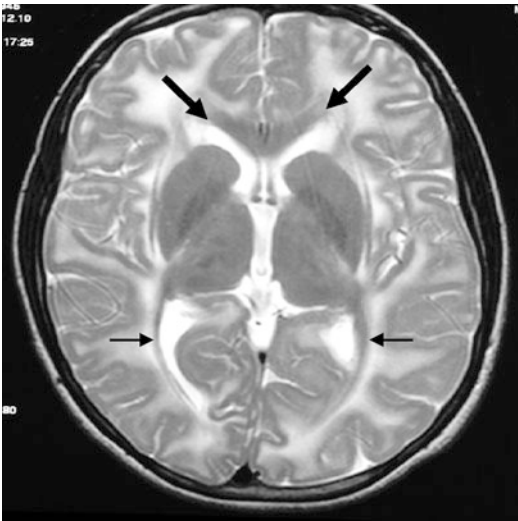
A 15-year-old Caucasian female was evaluated for megalencephaly and possible leukodystrophy. Early developmental status was normal except for the presence of macrocephaly. She had a bicycle accident with trauma to her head, followed by a generalized tonic-clonic seizure 7 months later. At 15 years of age, she had striking macrocephaly (head circumference of 65 cm), receiving special education, and was found to have mild bilateral clonus axial T1-weighted scan that demonstrates hyperintensity throughout cerebral white matter with sparing of the genu of the corpus callosum (*large arrowheads*), middle portion of the internal capsule, and the geniculocalcarine tracts (*small arrows*). Sequence analysis of the *MLC1* gene revealed two novel mutations. One mutation was inherited from the mother and was characterized by the substitution of adenine for guanine at nucleotide position 366 in exon 3. This mutation resulted in a change in the corresponding amino acid from arginine to histidine at amino acid position 84 (R84H). The other mutation was inherited from her father; it is in the canonical splicing site following exon 5 (538 + 1 g → a) and is expected to cause the transcription of a variant messenger ribonucleic acid (RNA) that can be translated into an altered protein. A 12-year-old brother was noted to have macrocephaly, seizures, significant learning difficulty, behavioral problems, increasing difficulty in ambulation, hyperreflexia, spasticity with positive Babinski reflexes, sustained clonus, and difficulty with tandem gait. His MRI showed a markedly increased T2-weighted signal throughout the supratentorial white matter with cysts in both temporal lobes in a pattern virtually identical to his sister's. Sequencing of the *MLC1* gene revealed the same mutations identical to his older sister (Courtesy of Dr. DMS Riel-Romero)
